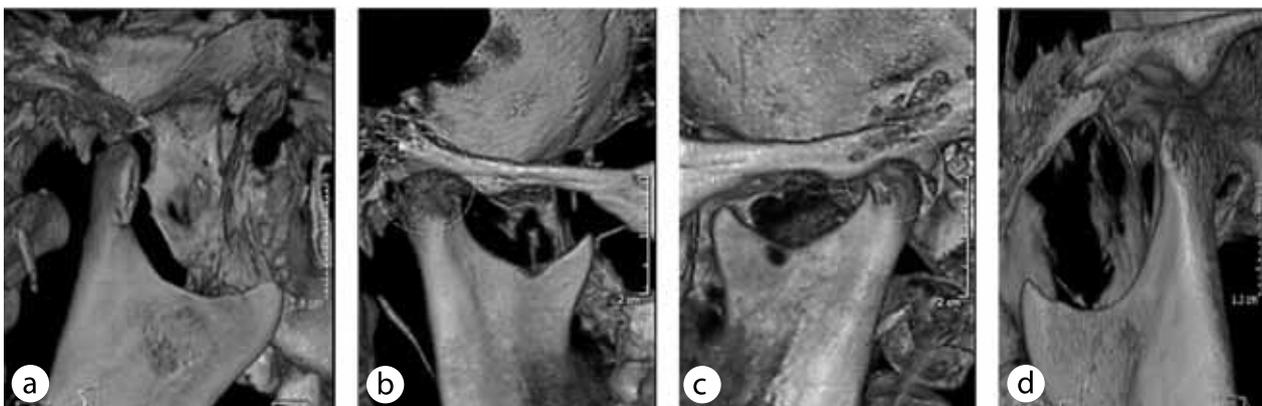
The temporomandibular joint image obtained through a CT scan in the open position (a — right, d — left) and closed (b — right, c — left)
